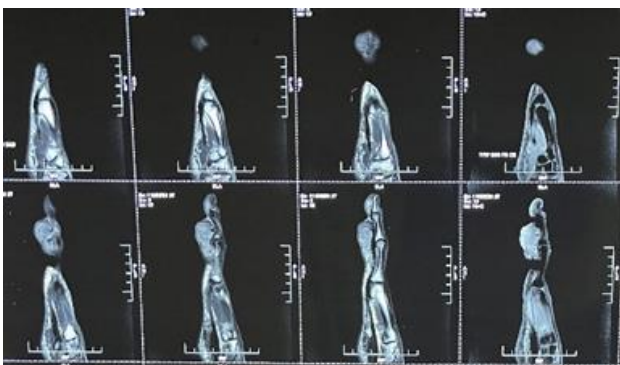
Preoperative MRI of the swelling
